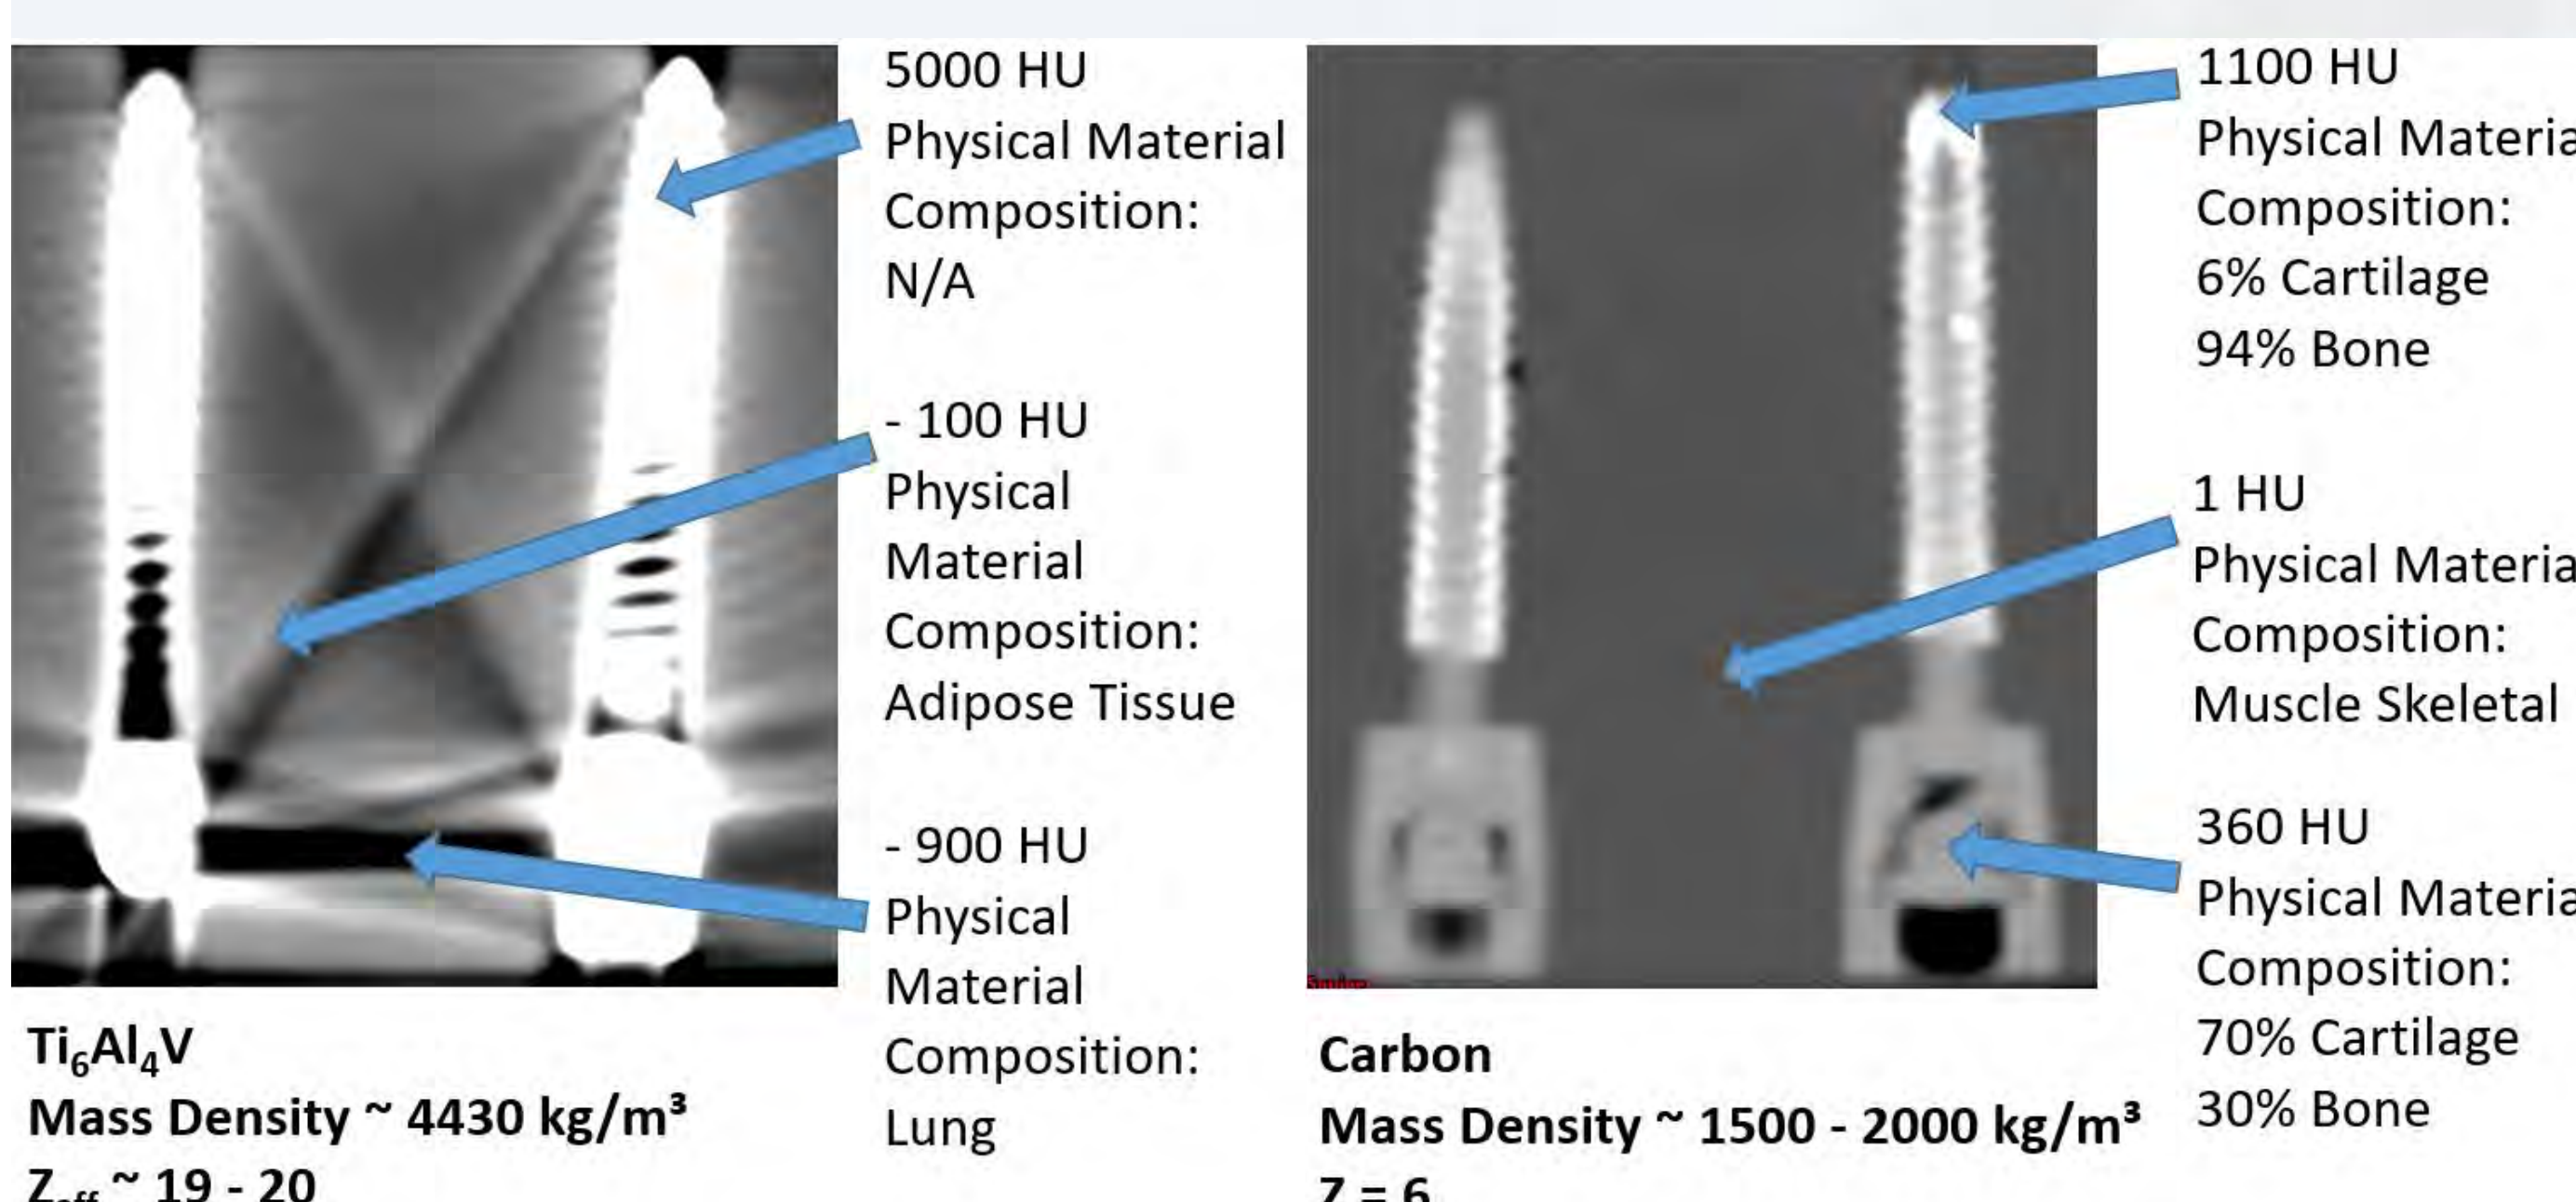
CT scan comparison of titanium (left) and carbon fixations (right).
